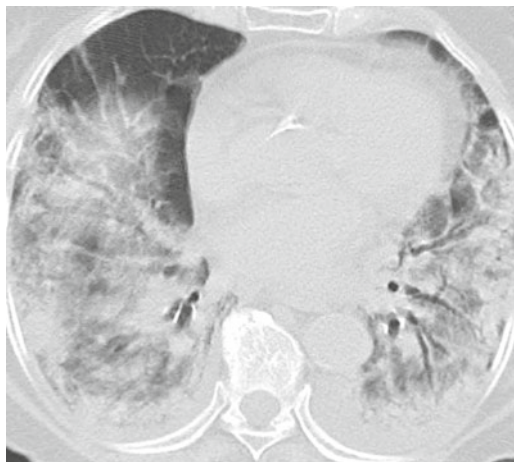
Cytosine arabinoside diffuse alveolar damage. An 80-year-old woman who had received cytosine arabinoside. CT images show diffuse, bilateral ground glass opacities and mild bronchiectasis. Pathology showed changes of diffuse alveolar damage and cultures were negative
